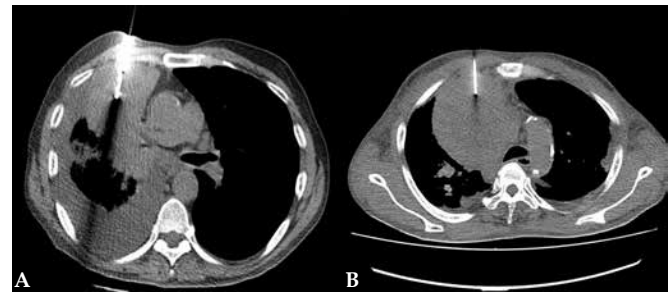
(A) Computed tomography-guided fine needle aspiration cytology (FNAC) showing peripherally located lung mass and (B) CT-guided core biopsy being done from a centrally located lung mass reaching up to the periphery.
